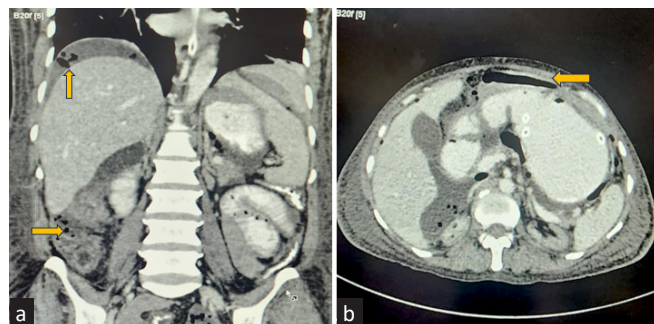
Contrast-enhanced computed tomography images (a) coronal view and (b) axial view showing multiple extra-luminal air attenuating foci in the non-dependant portion of the intra-peritoneal compartment of the abdomen (yellow arrows).
